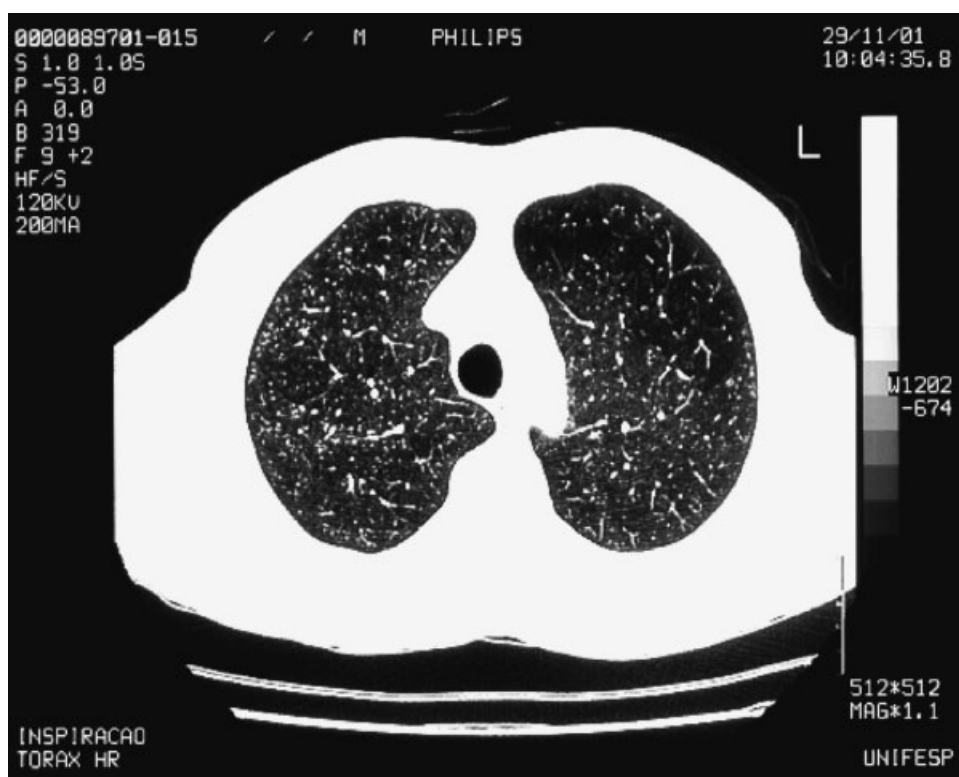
HRCT of case #3 showing intense and diffuse centrilobular well defined nodules.
